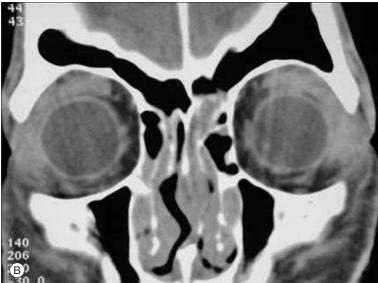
(A) An older man with unilateral left proptosis and eyelid swelling, lateral conjunctival chemosis, and yellowish discoloration of the eyelids due to adult onset xanthogranulomatous disease. This is usually bilateral. (B) A coronal CT scan from another patient with adult onset asthma and periocular xanthogranuloma (AAPOX) shows bilateral lacrimal gland infiltration with patchy extension into the adjacent soft tissues associated with paranasal sinus disease. (C) An axial CT of the patient in (A). (B) shows extension of the disease process along the lateral wall of the left orbit and extensive sinus disease.
